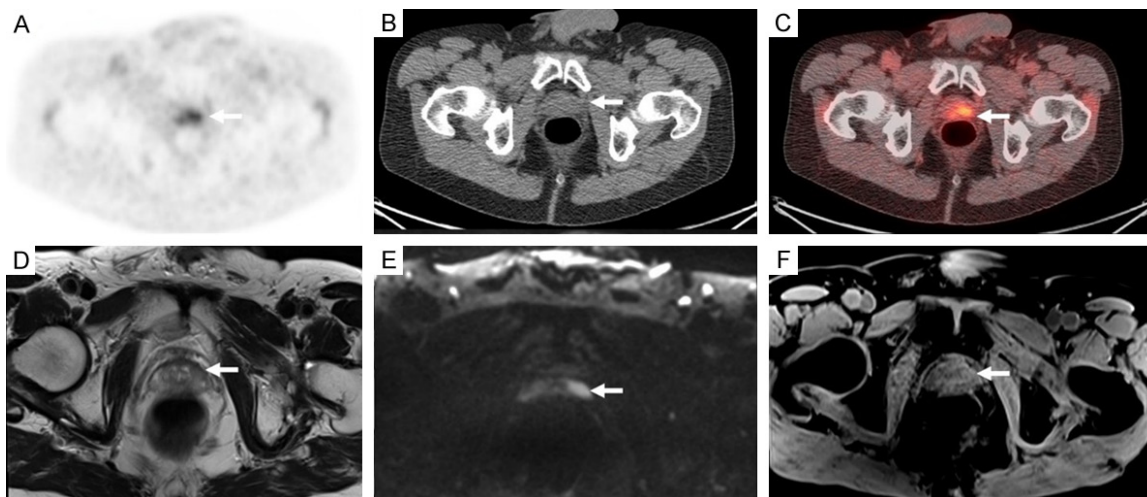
Axial ¹⁸F-fluciclovine PET (A), axial CT (B) and axial fused ¹⁸F-fluciclovine PET/CT (C) images of a 73-year-old male with Gleason 3+4 prostate adenocarcinoma, status post primary radiation therapy who was referred for a ¹⁸F-fluciclovine PET/CT examination due to rising serum PSA which was previously undetectable. His serum PSA at the time of the study was 0.18 ng/mL. ¹⁸F-fluciclovine PET/CT images demonstrate heterogeneous radiotracer activity within the prostate gland with asymmetric focal uptake (white arrows) in the left mid prostate gland (SUVmax 4.9). Axial T2-weighted MR (D), axial DWI-MR (E) and axial dynamic contrast enhanced (DCE) MR (F) of a pelvis MRI examination performed for further evaluation demonstrates a corresponding focal lesion which is hypointense on the T2-weighted images with restricted diffusion and heterogeneous contrast enhancement in the peripheral zone of the left mid prostate gland. Subsequent biopsy of the lesion demonstrated prostate adenocarcinoma (Gleason 3+4) with features of perineural invasion.
